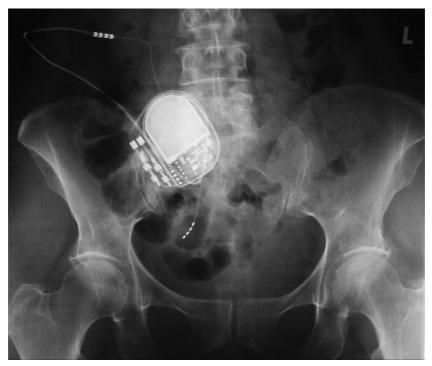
Pelvic radiograph of sacral nerve stimulator *in situ*. Reproduced courtesy of Medtronic.
